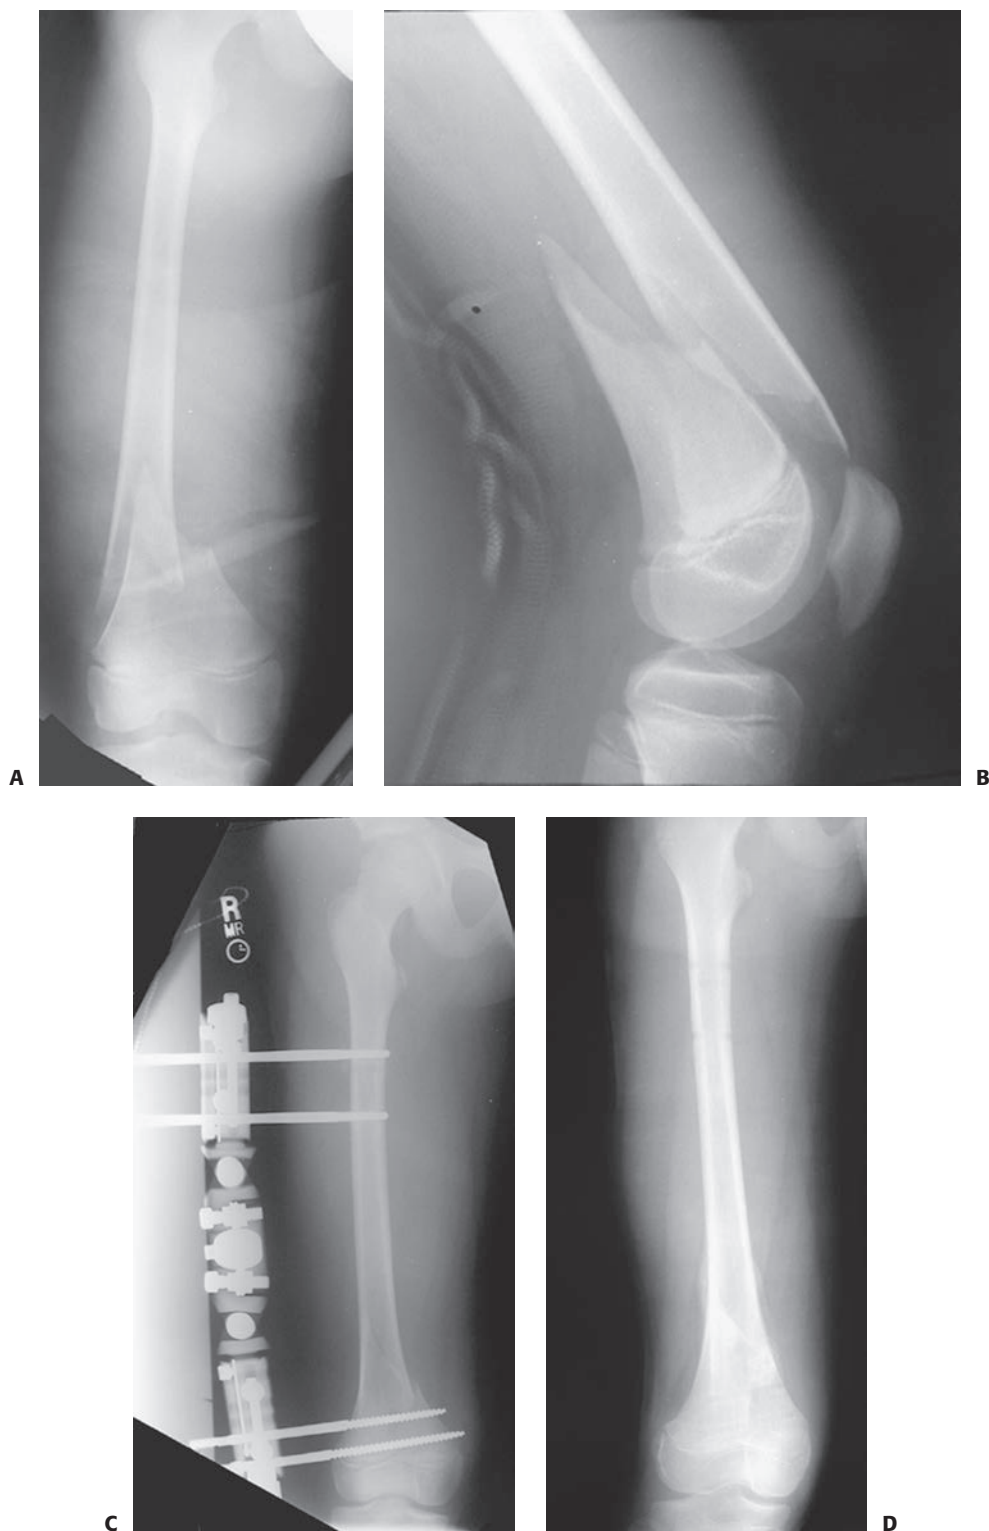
AP (A) and lateral (B) radiographs showing a fracture at the junction of the distal femoral metaphysis and diaphysis. C: The fractures reduced into near-anatomic alignment and an external fixator was used to control the distal fragment. D: The fixator was removed 8 weeks after injury, and after a brief period of weight bearing is tolerated a long leg cast, the fracture has healed in anatomic alignment with no shortening.
